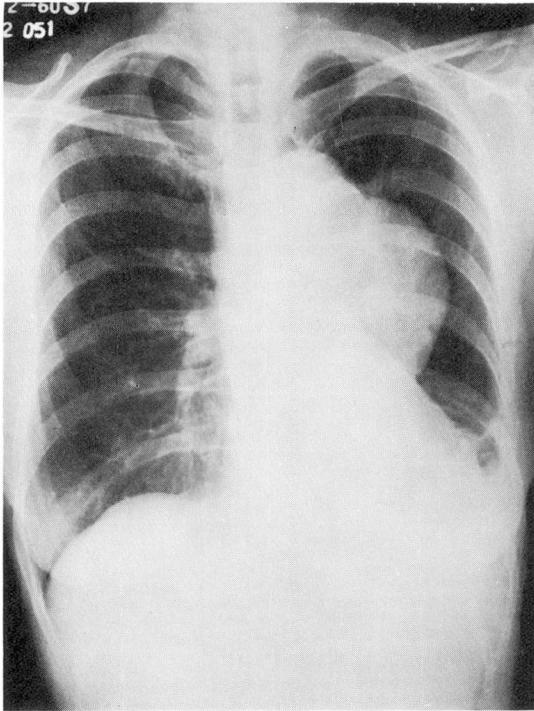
Roentgenogram of what proved to be a localized dissecting aneurysm in a 68-year-old woman. Operative removal and graft were uneventful, but in the immediately postoperative period in this patient a fresh full-thickness dissection developed immediately above the upper anastomotic line, and she died.
